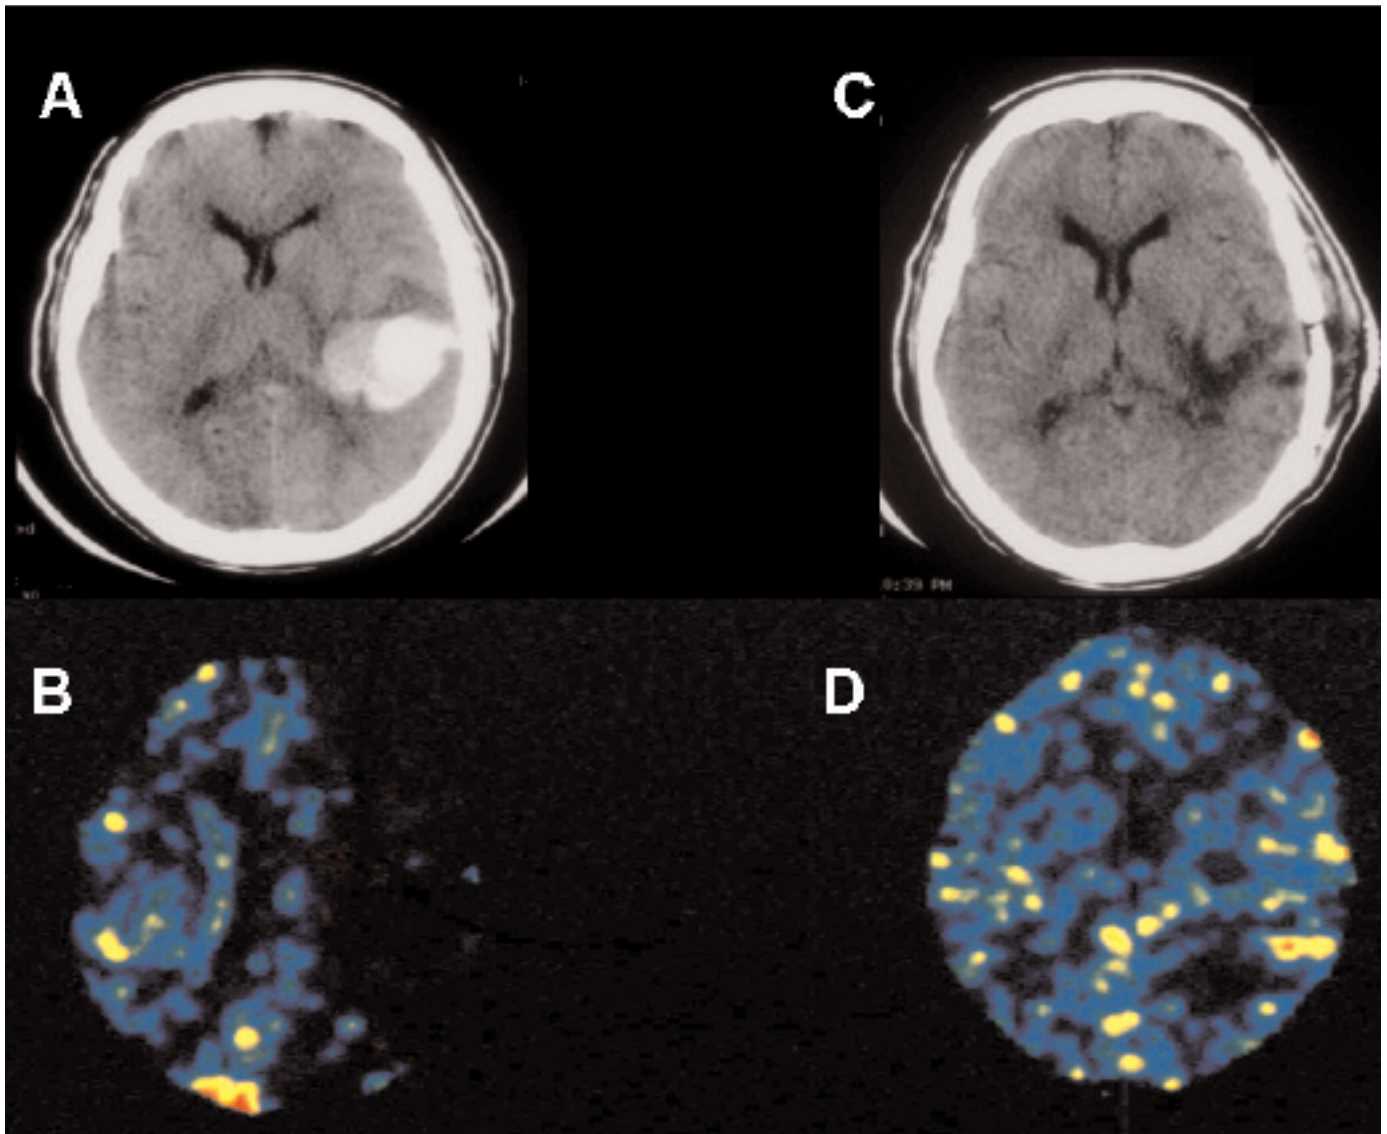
Perihematomal ischemia and acute sSICH delineated on CT scan (A) is surrounded by an extensive area of hypoperfusion as demonstrated on a concurrent stable Xenon cerebral blood flow study (B) early clot evacuation (C) resulted in major neurologic improvement and correction of perihematomal ischemia (D) as documented 12 hours postoperatively.
